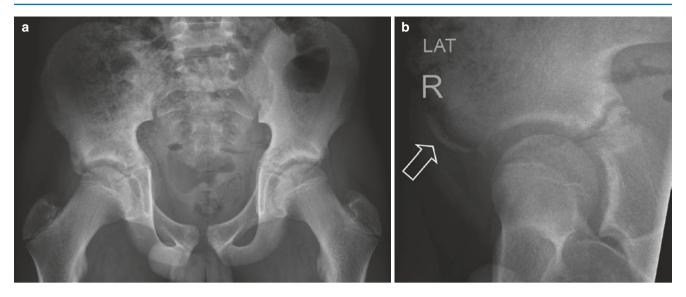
Fifteen-year-old soccer player with acute pain in the hip. (a) Radiograph of the pelvis shows a cortical irregularity at the level of the anterior inferior iliac spine (AIIS). (b) Axial hip shows an avulsion fracture of the AIIS (arrow)
